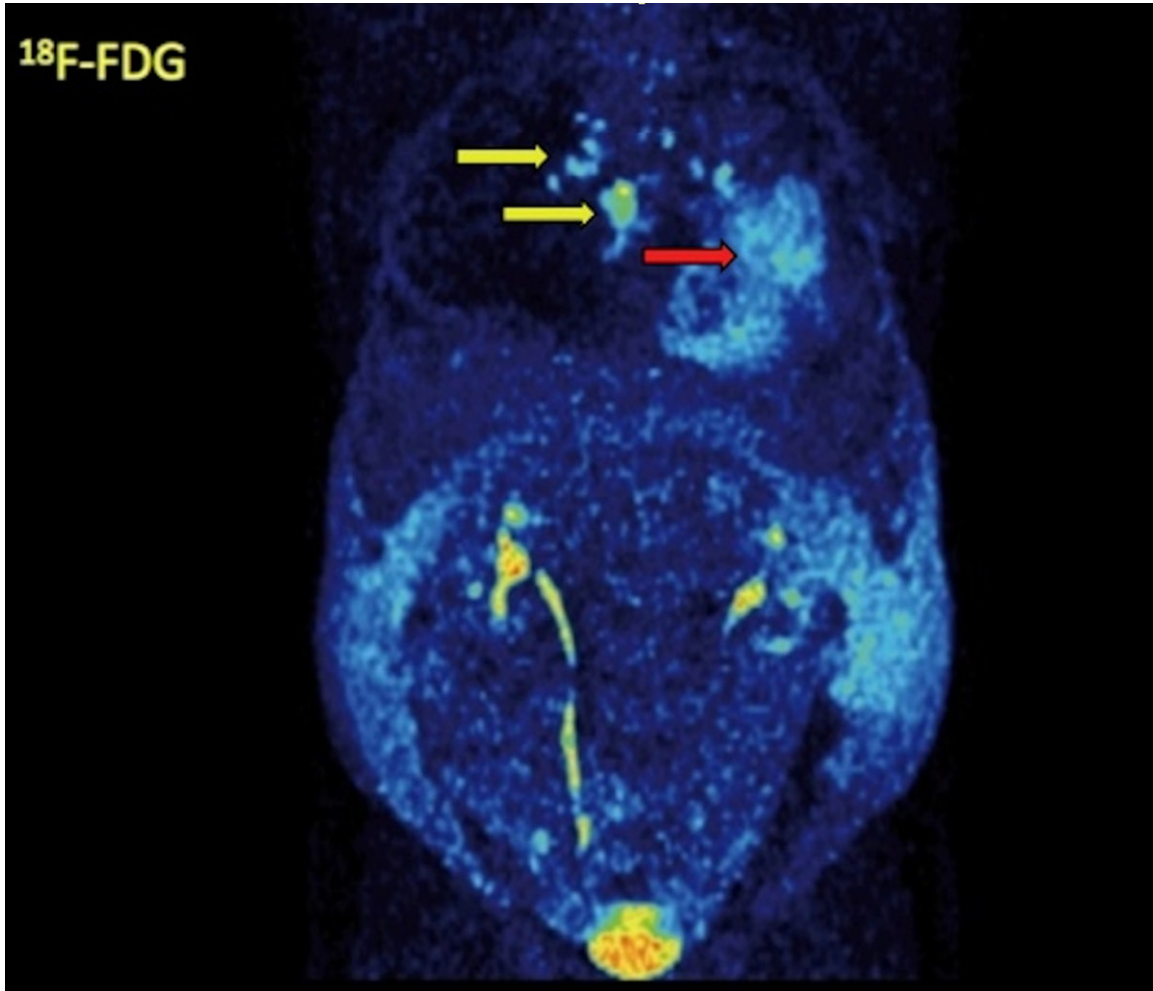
MIP images of ¹⁸F-FDG PET/CT (upper row) and ¹⁸F-FMISO PET/CT (lower row) of the same patient as in Figure 3. The patient demonstrates, apart from the primary tumor (red arrow), metastases to contralateral mediastinal lymph nodes and the sternum (yellow arrows), which are depicted, however, only with ¹⁸F-FDG PET/CT and not with ¹⁸F-FMISO PET/CT. The patient developed also ascites due to the malignancy.
